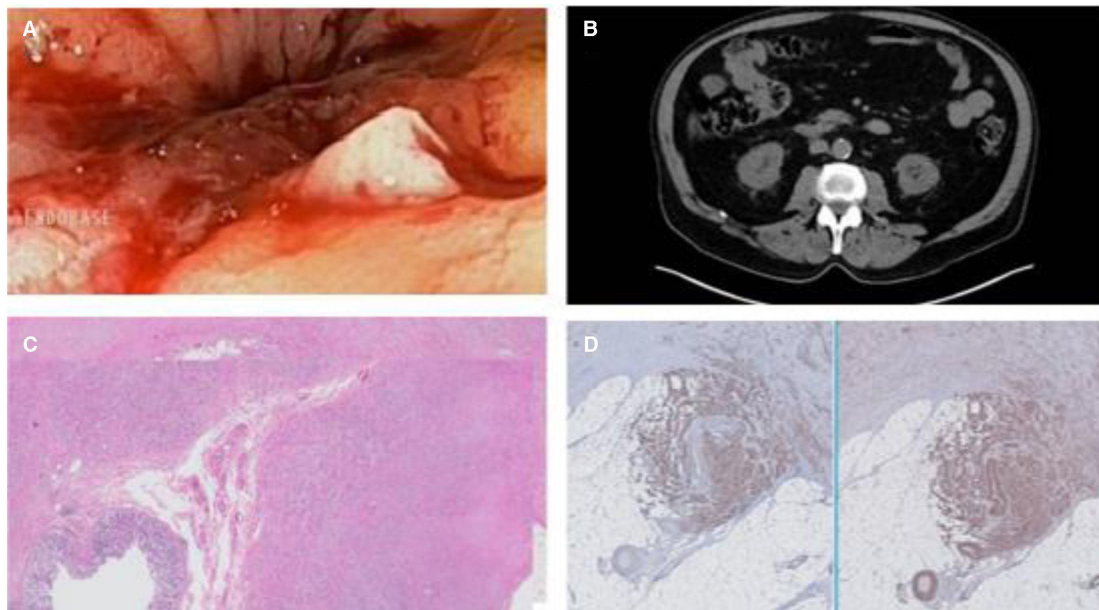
(A) shows the endoscopic image of an impassable stricture with adenomatous edges and friable when touched by the endoscope. (B) CT image showing a mass in the transverse colon that narrows the intestinal lumen, without retrograde dilation. (C and D) Anatomopathologic study confirming the presence of a colonic leiomyosarcoma, positive for actin and desmin, and negative for GIST markers, such as CD117.
